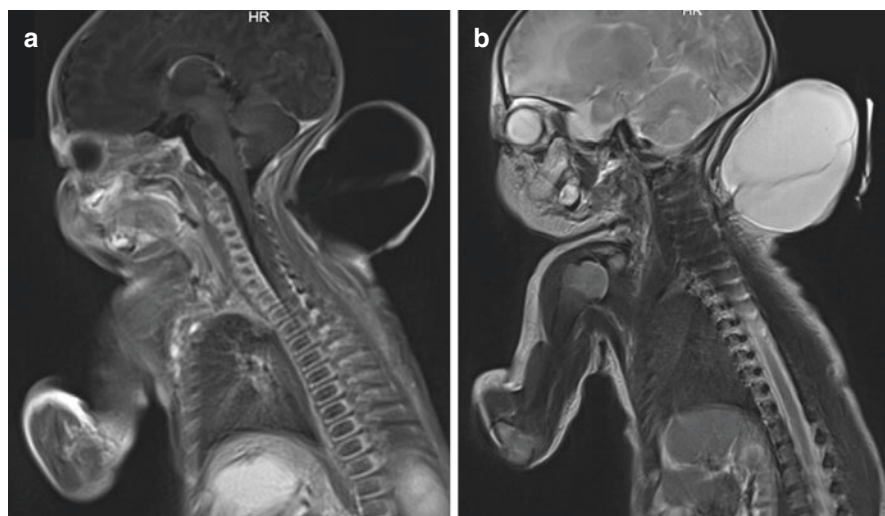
(a) T1-weighted and T2-weighted (b) MRI of an infant with a cervical meningocele
